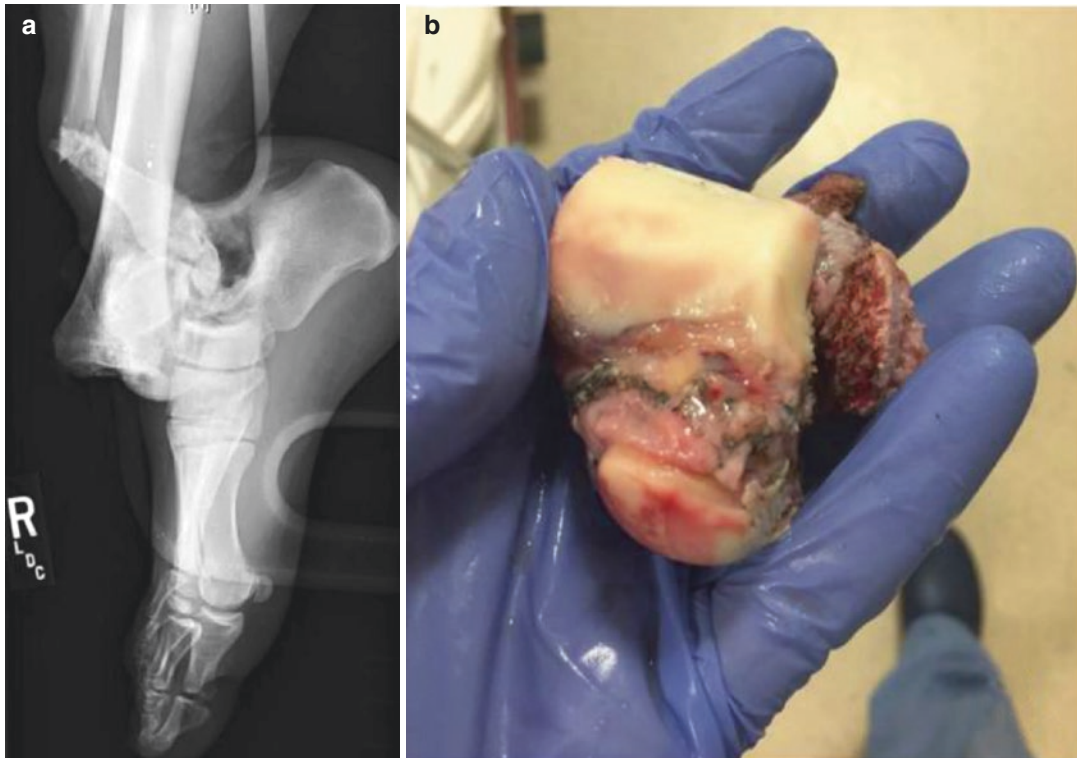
(a, b) An injury X-ray (a) and clinical photo (b) demonstrating an open pantalar fracture dislocation with complete extrusion of the talus and an associated bimalleolar ankle fracture
